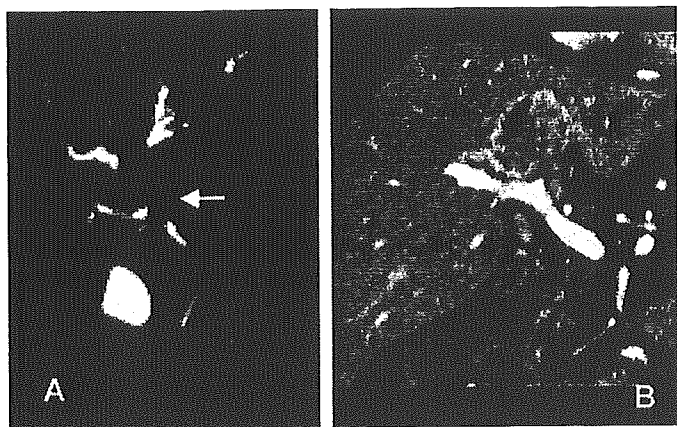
A.* Magnetic resonance cholangiography revealed the dominant site of bile duct carcinoma involvement of the left hepatic duct, extending close to the bifurcation of the anterior duct. The posterior hepatic branch (arrow) was separated from the common bile duct (Case 9). *B.* Dynamic computed tomography revealed cholangiocellular carcinoma centrally located close to the root of the right anterior pedicle. The right hepatic duct, which runs along the upper edge of the hilar plate, could not be preserved (Case 10).
